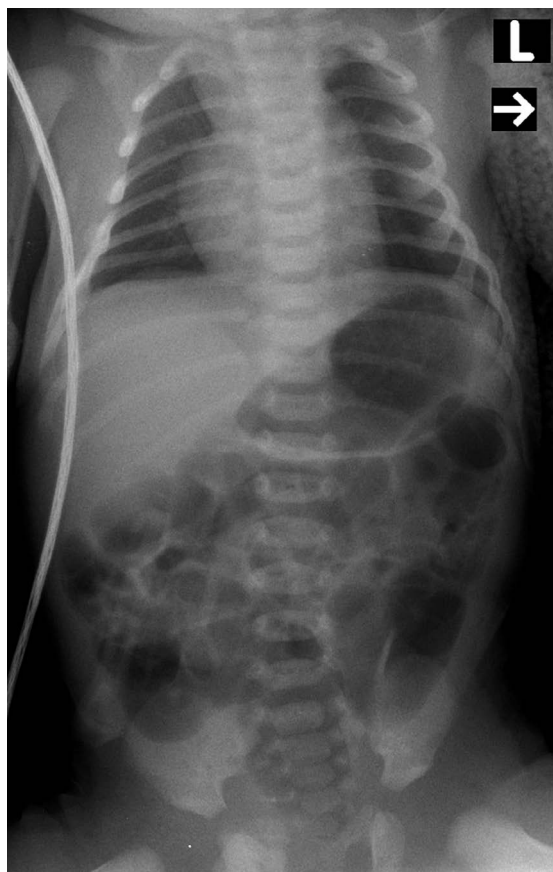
Chest X-ray of the heart of the newborn on the first day of post-natal life. The heart has an unusual presentation with no typical apex; however, cardiomegaly is not present
